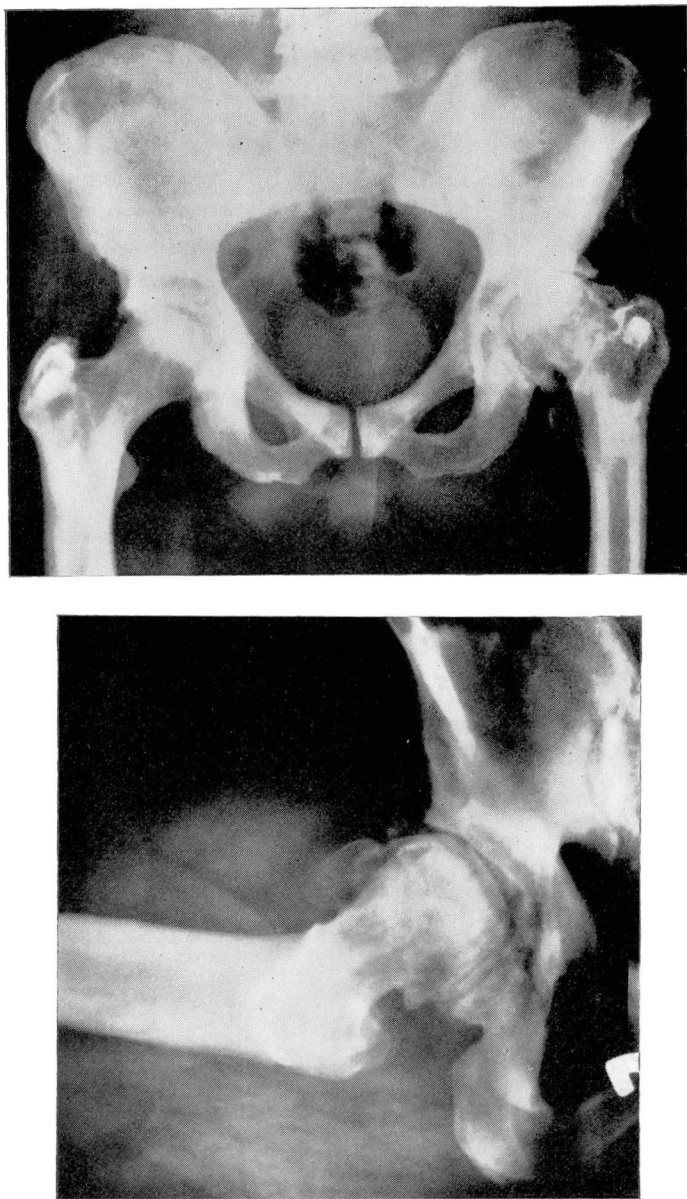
A, *upper*, Roentgenogram of pelvis showing increased density and concentric sclerotic rings of the ilia and the features of osteoarthritis of the left hip. B, *lower*, Lateral roentgenogram of the left hip more clearly showing the classic changes of osteoarthritis.
